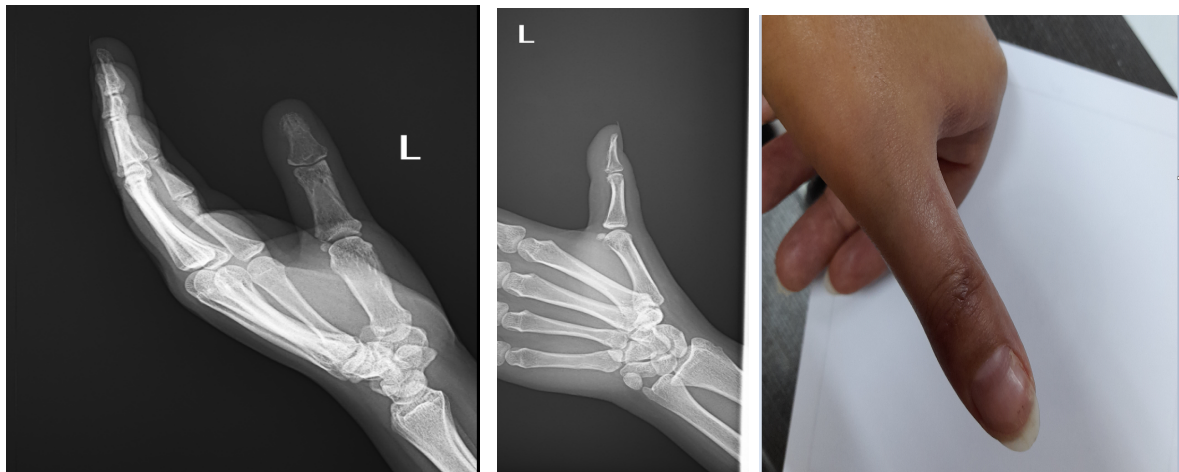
The photo and x-ray of the thumb seven months after surgery
